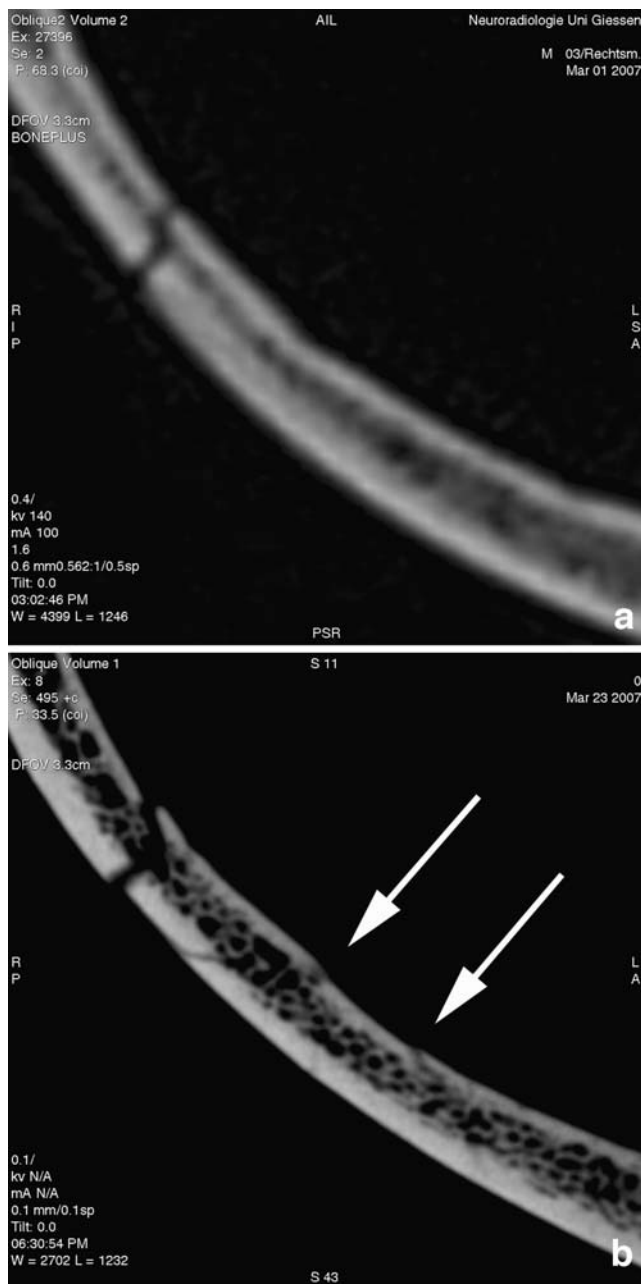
a, b Comparison of two corresponding cross-sections from the MSCT (a) and eLU-CT data sets (b) for the area in the region from Fig. 1. The large fracture line at the *top left* can be discerned in both images. Apart from that, no further injuries are depicted for the MSCT. In the eLU-CT, a fragment from the inner table of the skull can be seen, which has been displaced toward the diploic bone and is bordered on both sides by minute fracture lines extending outward in the shape of a funnel
